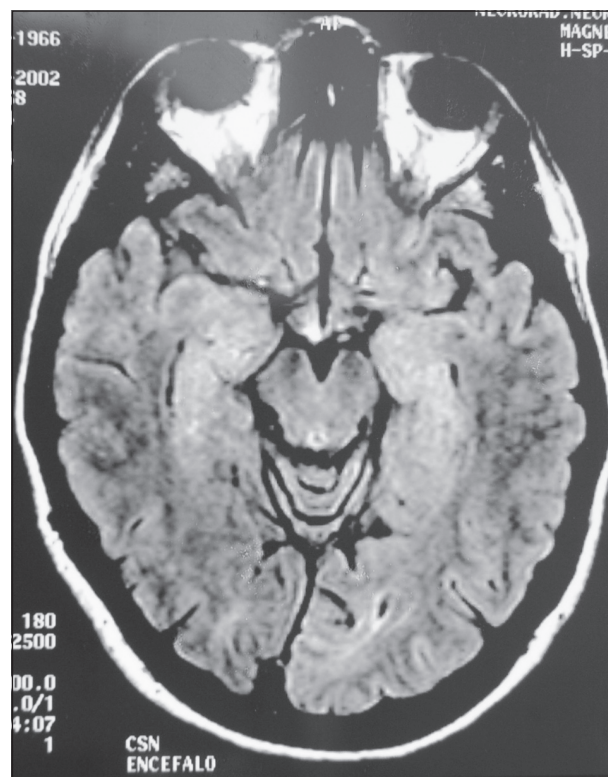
Control MRI performed nine days later, showing the almost complete resolution of oedema.
